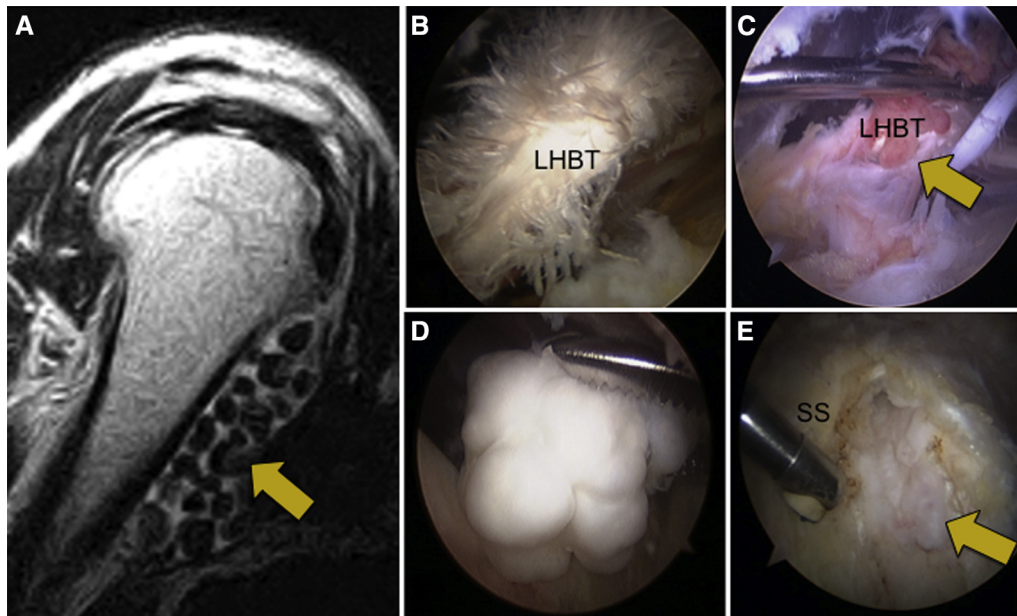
The extra-articular bicapital tunnel is a closed space in which lesions such as loose bodies can aggregate (A, arrow) as seen on this sagittal view magnetic resonance image. Several different space-occupying extra-articular lesions have been identified within the bicapital tunnel at the time of transfer of the long head of the biceps tendon (LHBT) to the conjoint tendon in symptomatic patients that would not have been visualized arthroscopically, including partial tears (B), adhesion and scar formation (C, arrow), loose bodies (D), and osteophyte formation (E, arrow). SS, subscapularis.
